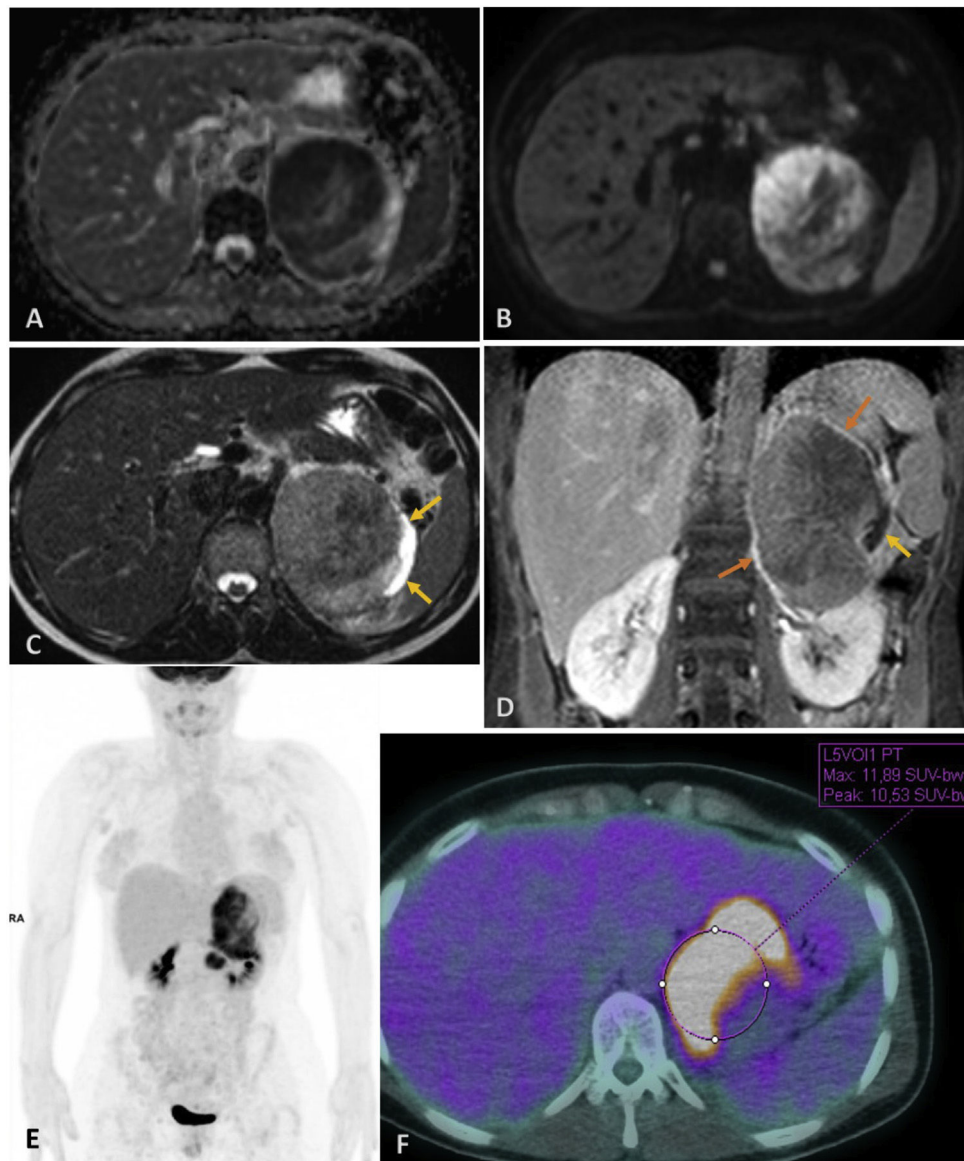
Abdominal MRI, ADC map (A), diffusion (B), axial T2-weighted images (WI) (C) and coronal T1WI with fat suppression after gadolinium administration, delayed phase (D) presents a mass with restricted diffusion and predominantly intermediate signal on T2WI, with an eccentric cystic component suspicious of necrosis (yellow arrow). Post-contrast images show delayed mild enhancement, with a thin enhancing rim, resembling a pseudo-capsule (orange arrow). PET/CT demonstrates that the mass is ^{18}F -FDG-avid, with a high uptake value and the areas of greater avidity corresponding to the areas of restricted diffusion on MRI. PET/CT also confirms that disease is localized to the left upper retroperitoneum, with no signs of distant metastases.
